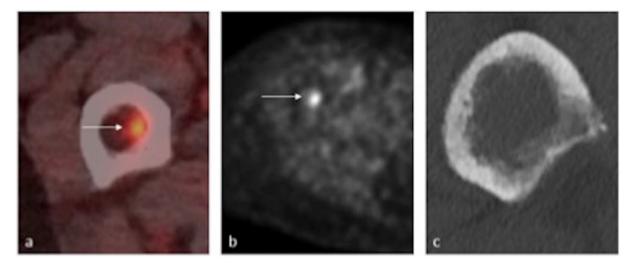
A 65 year old female with right thigh pain. FDG PET CT fused axial images (a) and MIP images (b) shows avid uptake along the medial aspect of the right proximal femur. The CT component (c) showed an aggressive permeative appearance to the endosteum with expansion of the medullary cavity by a lesion. No further lesion was identified on the rest of the study. CT biopsy confirmed a metastatic deposit, with cervical cancer being the likely primary.
